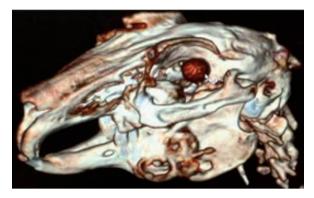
MRI of the bone tissue of the lower jaw
